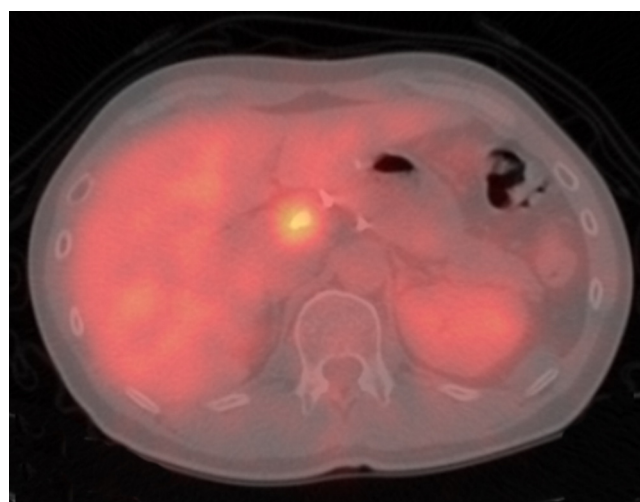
Positron emission tomography with 2[18 F]-fluoro-2-deoxy-d-glucose (FDG) shows a mass with SUVmax of 4.48 (arrow), consistent with the CT scan findings.
